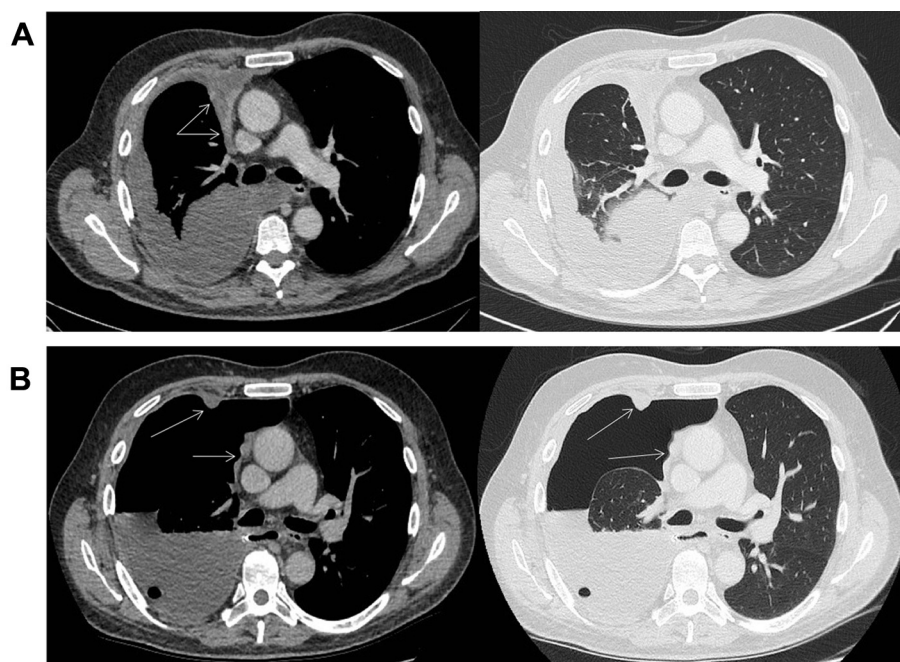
A, Axial CT images just below the level of the main carina show reduced right hemithorax volume with pleural effusion and barely visible anterior and mediastinal pleural nodules (arrows). B, Drainage of the pleural fluid with resultant pneumothorax (visible on lung windows) highlights prominent areas of pleural thickening (arrows).
